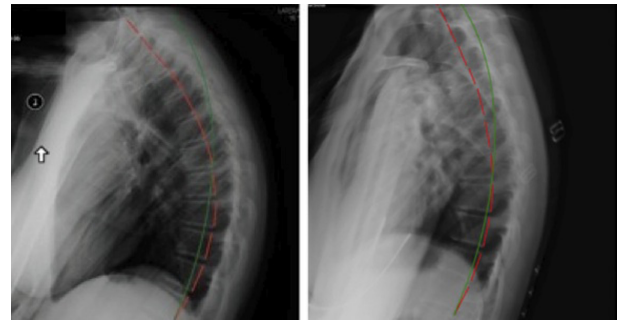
Thoracic spine radiographs
